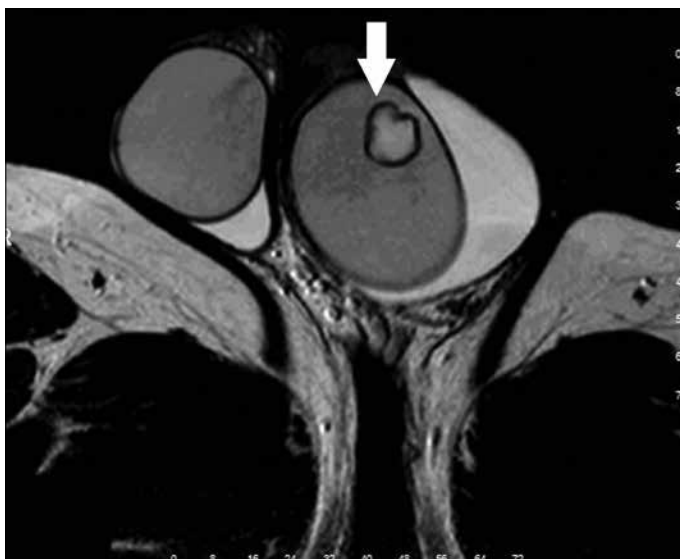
Intratesticular mass seen in the MRI (arrow)
